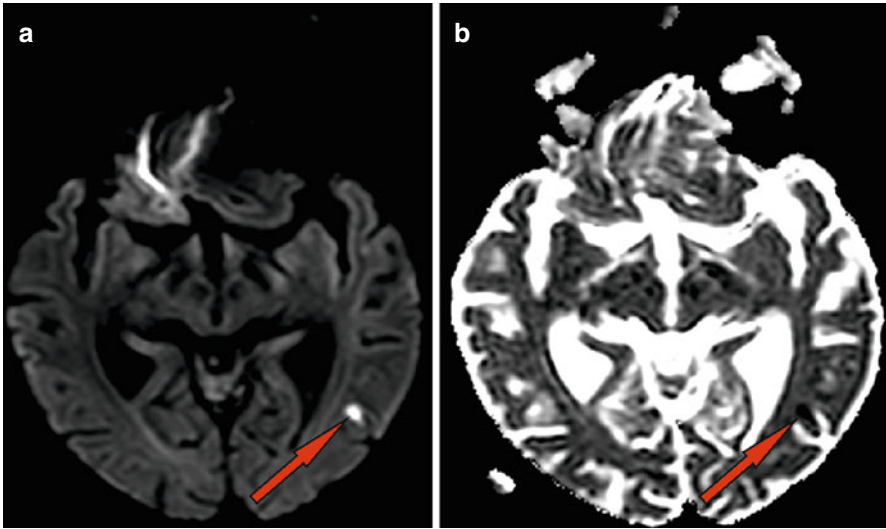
DWI-MRI imaging of small LACI stroke in subcortical white matter close to the left inferior temporal gyrus (*red arrows*) with high-intensity signal in DWI-MRI ($b=1000$) sequence (a) and corresponding DWI low-intensity signal in the MRI ADC map (b)
